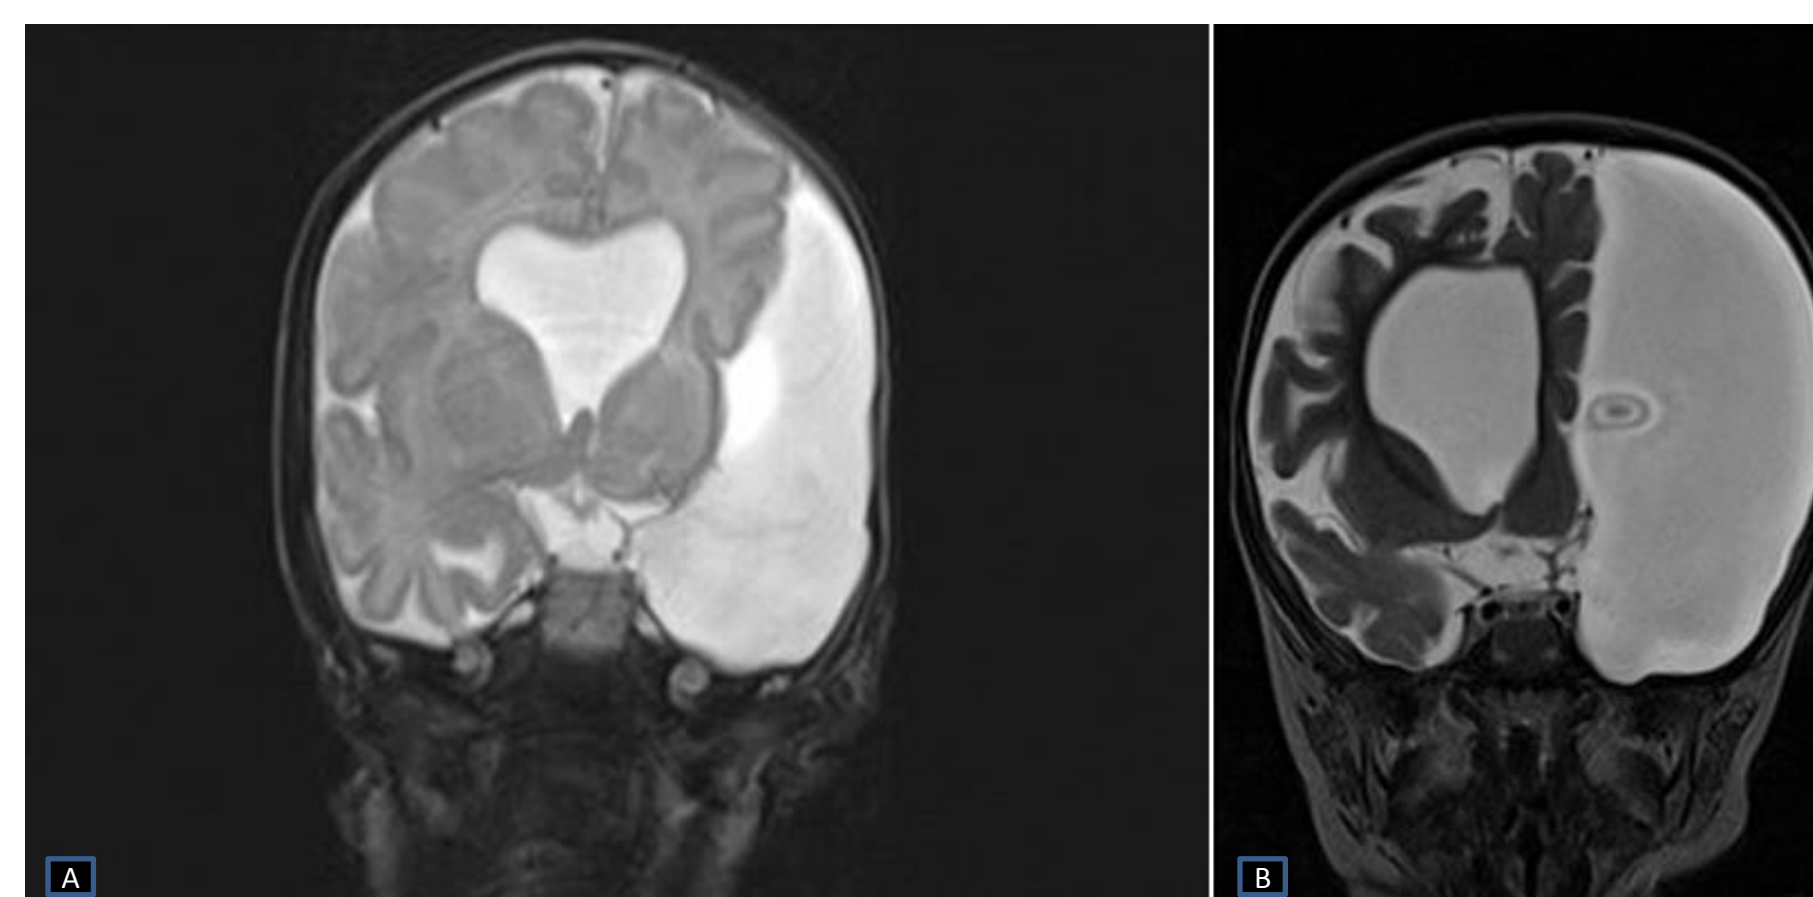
MRI Brain coronal T2 pre (A)- and post (B) acute hydrocephalus
